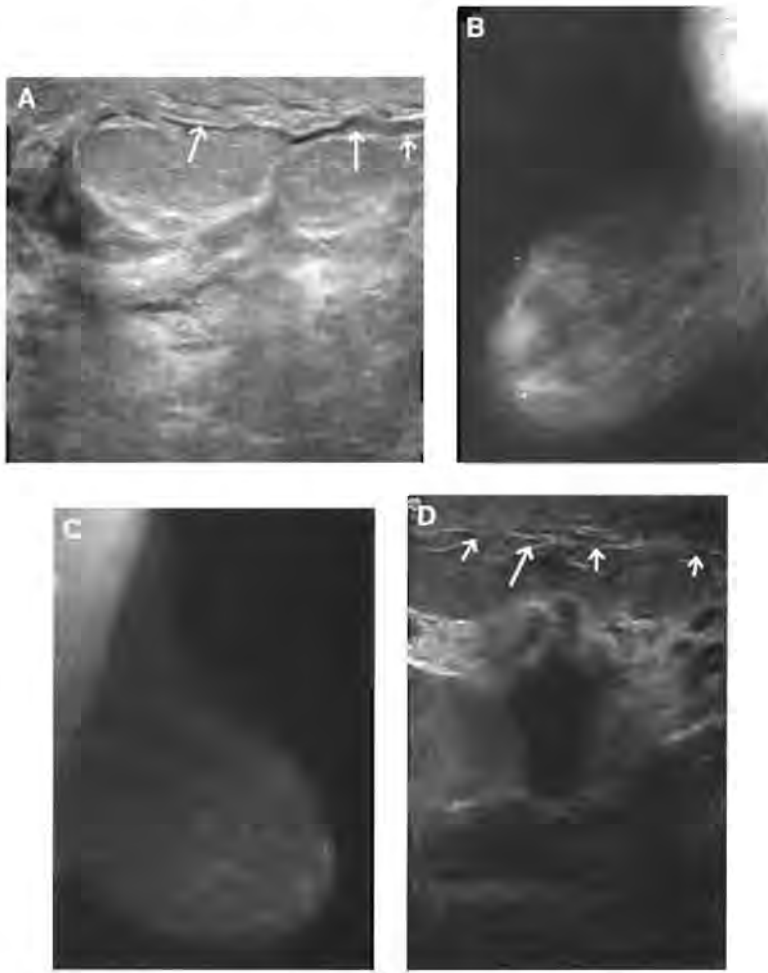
Inflammatory carcinoma. (A) Sonogram shows skin thickening (*short arrows*) and edema (*long arrows*), the hallmarks of inflammatory carcinoma. (B, C) Mediolateral oblique mammograms of another patient show increased density, edema, and skin thickening of the right breast compared with the left. (D) US image is brightly echogenic, characteristic of edematous tissue, with thickened skin (*short arrows*) and network of hypoechoic lines representing interstitial fluid or lymphatics (*long arrows*). Note a small, irregularly shaped hypoechoic mass (*), invasive ductal carcinoma, not well seen on the mammogram.
